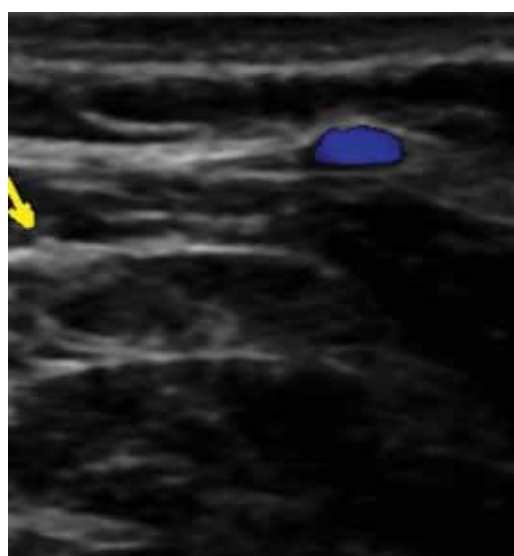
Ultrasound picture; cross section of GAN in approximately 1 cm lateral to jugular vein.
